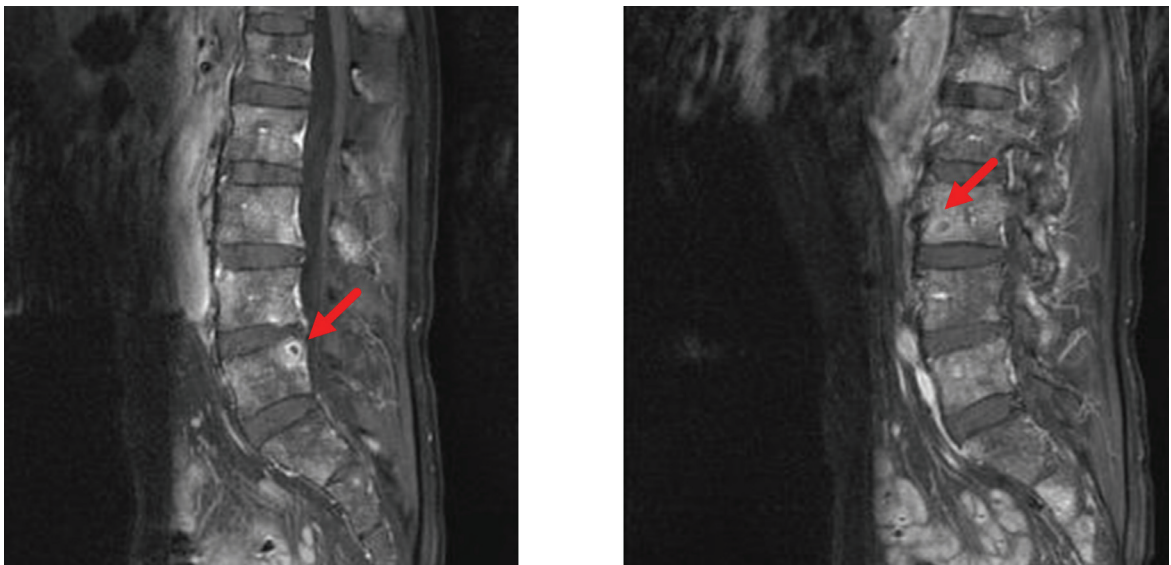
Magnetic resonance imaging of the lumbar spine with T1-weighted contrast imaging reveals multifocal small fluid-like nodular lesions with rim gadolinium enhancement at the L3 and L5 spine.
